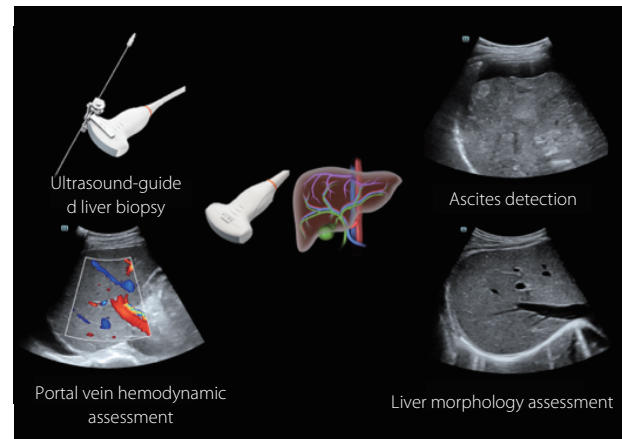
Convex Array Probe Equipped to Provide Comprehensive Color Doppler Ultrasound Imaging
